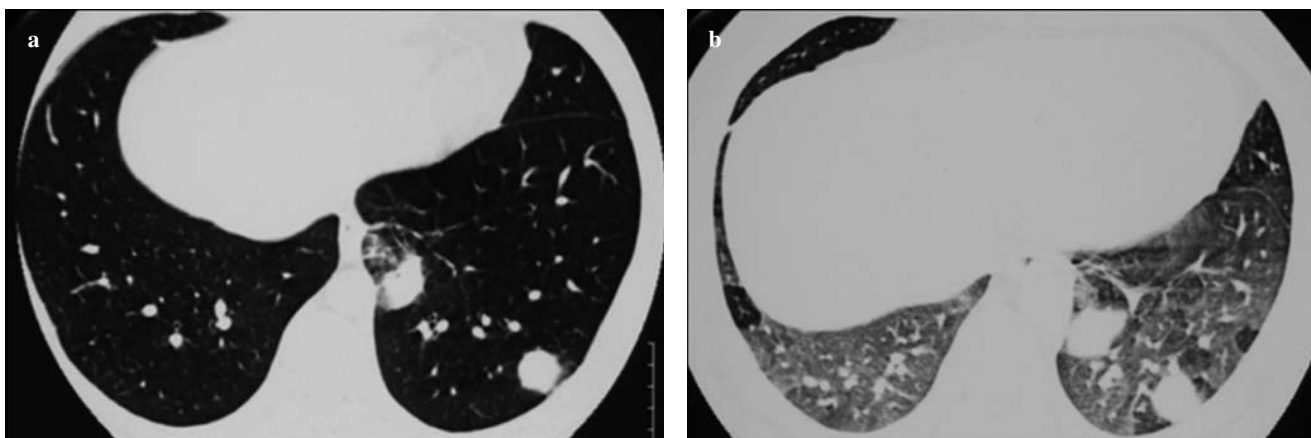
Inspiratory chest high-resolution computed tomography (HRCT) scan. In the left lower lobe, a large nodule with peripheral ground-glass opacity can be seen. b Expiratory HRCT at the same level shows geographically distributed areas of air trapping in both lung bases.
